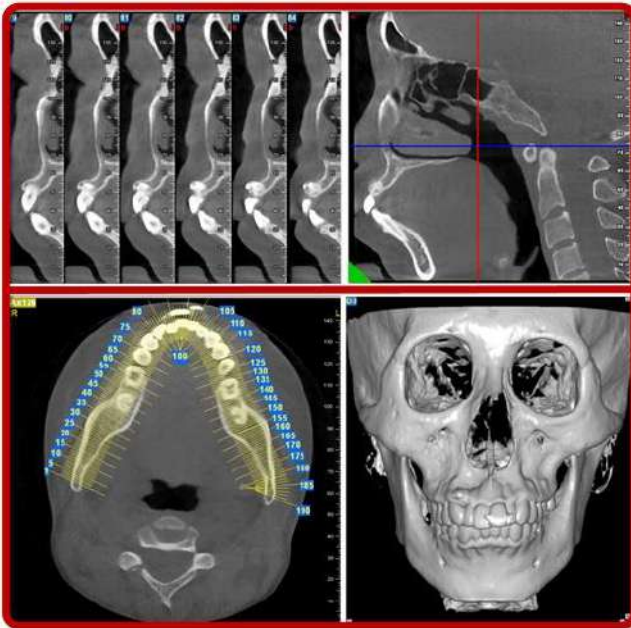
Computer Tomography (CT) scan of patient.
